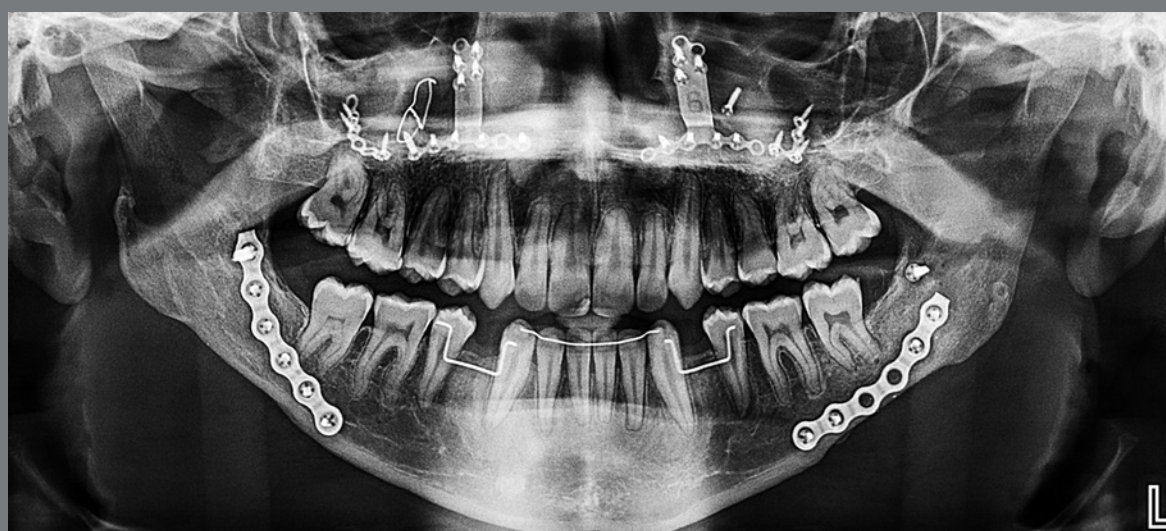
Final panoramic radiograph.
